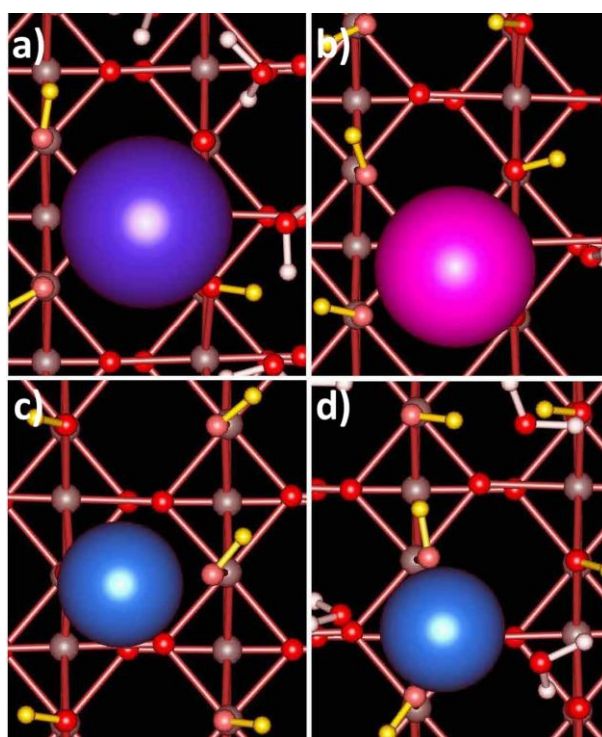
Top view of the rutile (110) hydroxylated surface. Tetradentate adsorption sites for a) Rb^+ and b) Sr^{2+} and bidentate adsorption sites for Zn^{2+} between c) bridging and terminal oxygens and d) two terminal oxygens. The adsorbed ions are shown larger than other atoms for clarity. Only water molecules not farther than the adsorbed ions from the surface are shown. Color code: Ti: brown, O: red, H_2O : white, H (surface hydroxyls): yellow. Reprinted with permission from Předota, M. et al. 'Electric Double Layer at the Rutile (110) Surface. 2. Adsorption of Ions from Molecular Dynamics and X-Ray Experiments'. *J. Phys. Chem. B* 2004, 108 (32), 12061–12072. © 2004 American Chemical Society.
